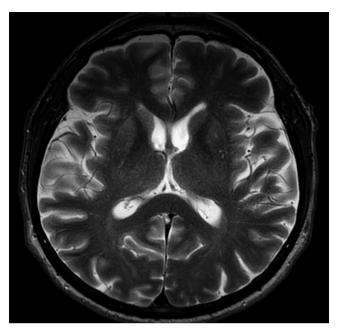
Axial T2-weighted MRI shows preserved gray-white matter contrast without significant atrophy or signal changes. The absence of abnormalities supports the specificity of DWI hyperintensities typical in prion disease.
